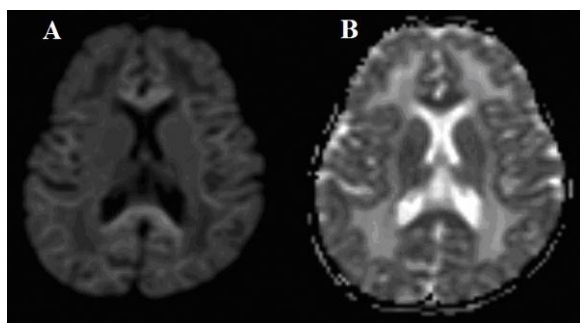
(A and B) Diffusion weighted image and apparent diffusion coefficient magnetic resonance images respectively, shows no diffusion restriction of the involved white matter.
